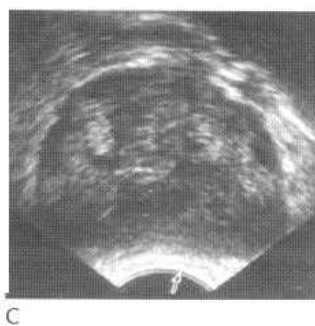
Transrectal ultrasound (transverse image) showing multifocal echo-poor prostatic cancer (two nodules identified by arrowheads).
